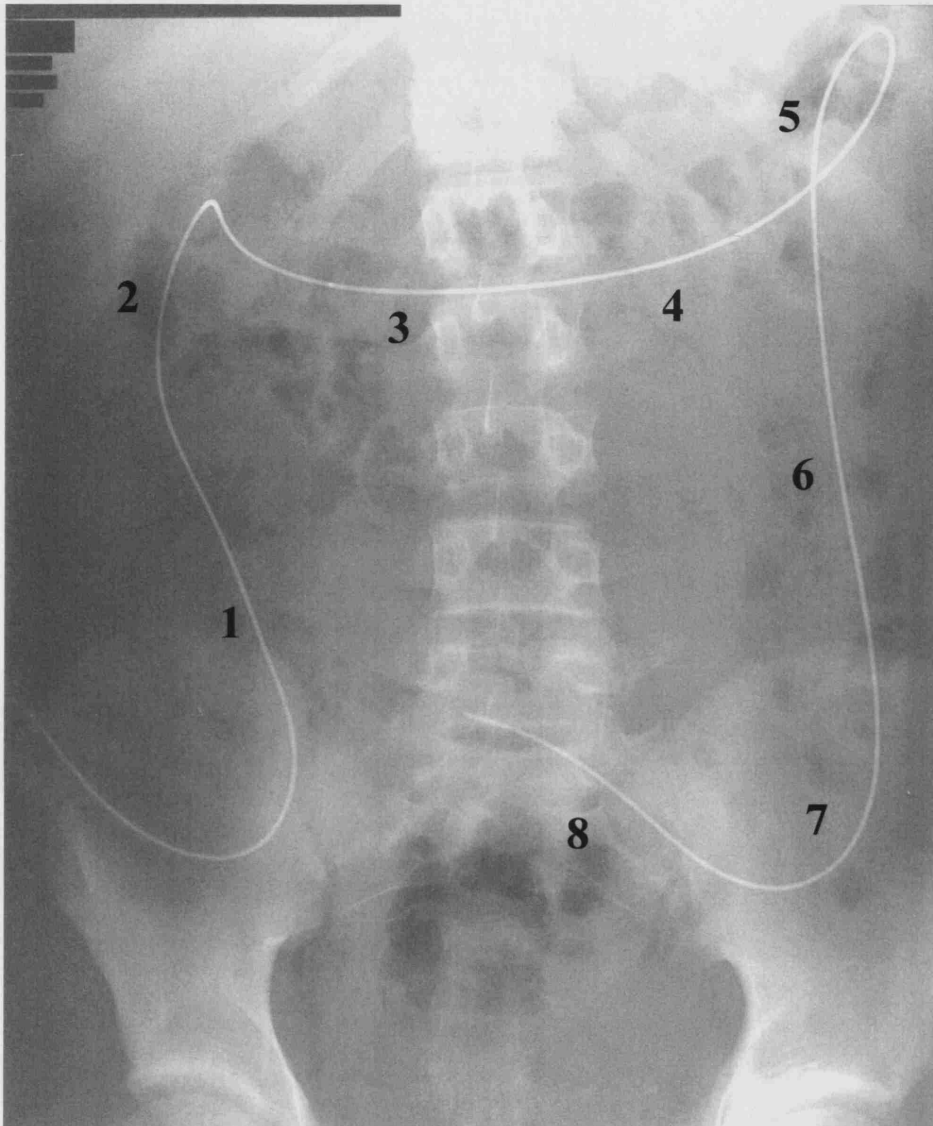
Abdominal X-ray showing position of 8 sidehole colonic manometry catheter. The catheter has been inserted via the appendicostomy and the tip is positioned in the distal sigmoid colon. Numbers 1-8 indicate the position of the sideholes, spaced at 7.5 cm intervals from the appendix (1) to the distal sigmoid (8).
